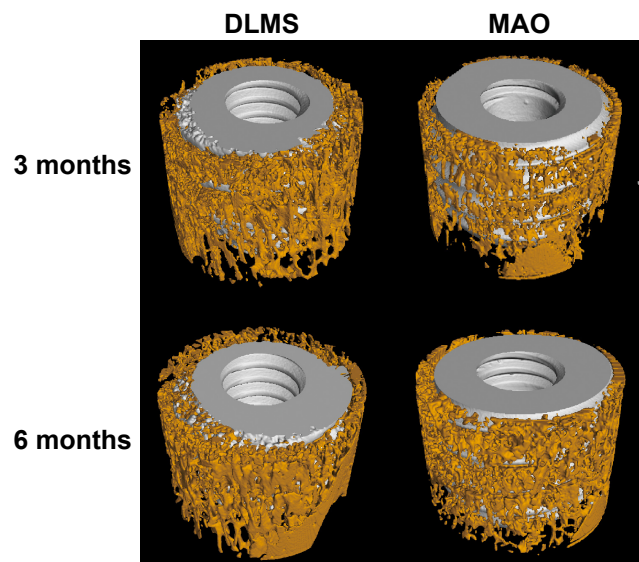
Micro-computed tomography analysis of osteogenesis of DLMS and MAO implant 3 and 6 months after surgery. This shows the three-dimensional reconstruction of the samples.
